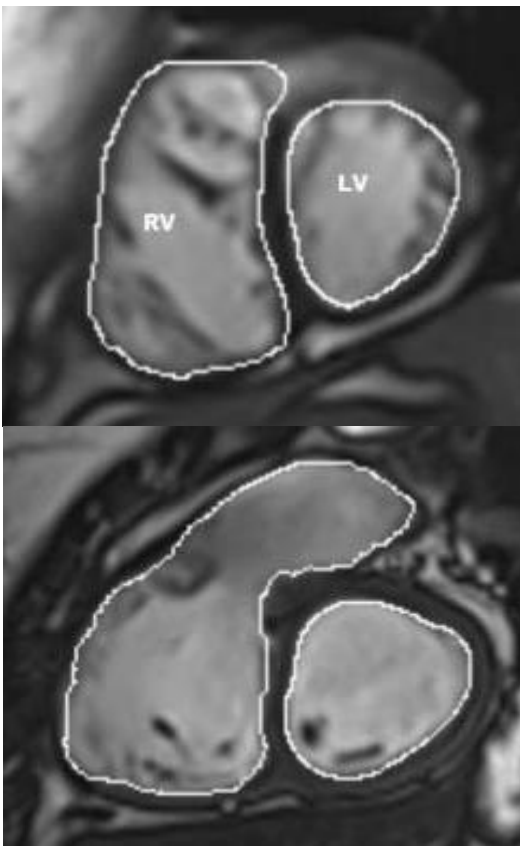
Cardiac MRI endocardial tracing for ventricular volumetric measurements.
